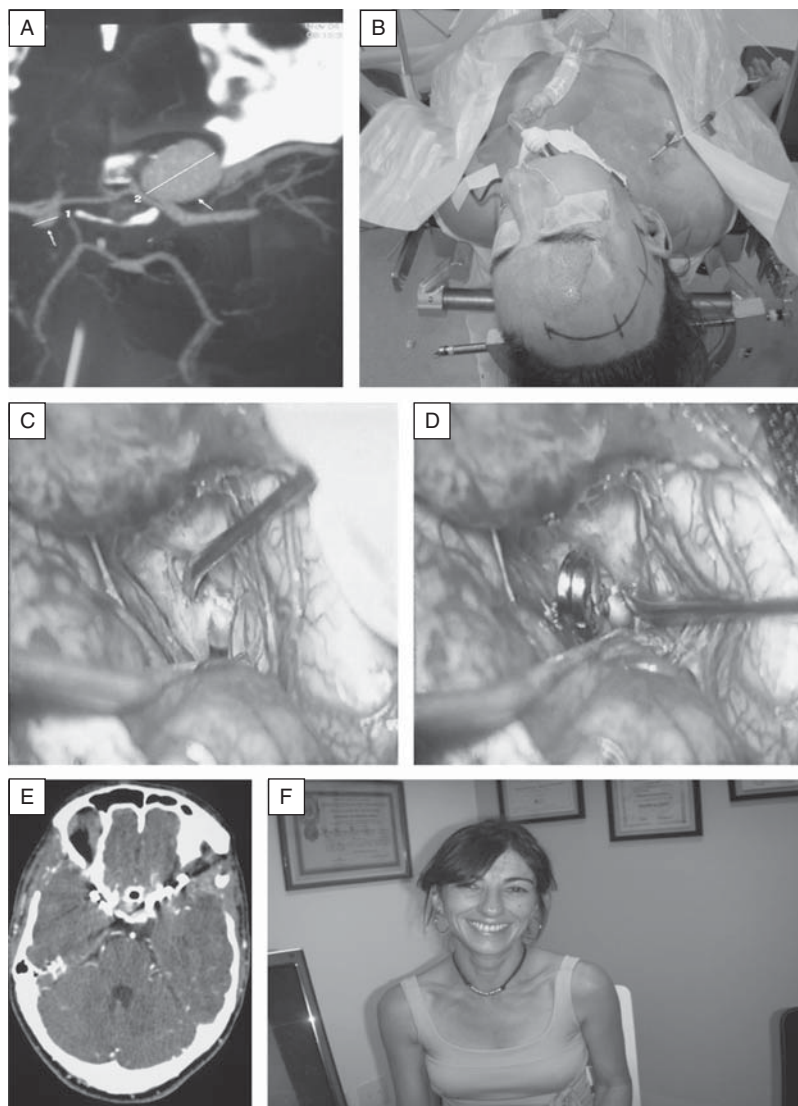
A, Magnetic resonance angiography showing a giant posterior communicating artery aneurysm Type IVA; (B) preoperative positioning. C, Visualization of the aneurysm after lateral fissure opening. D, Aneurysm view after clipping; (E) CT after surgery. F, Patient after aneurysm clipping.
